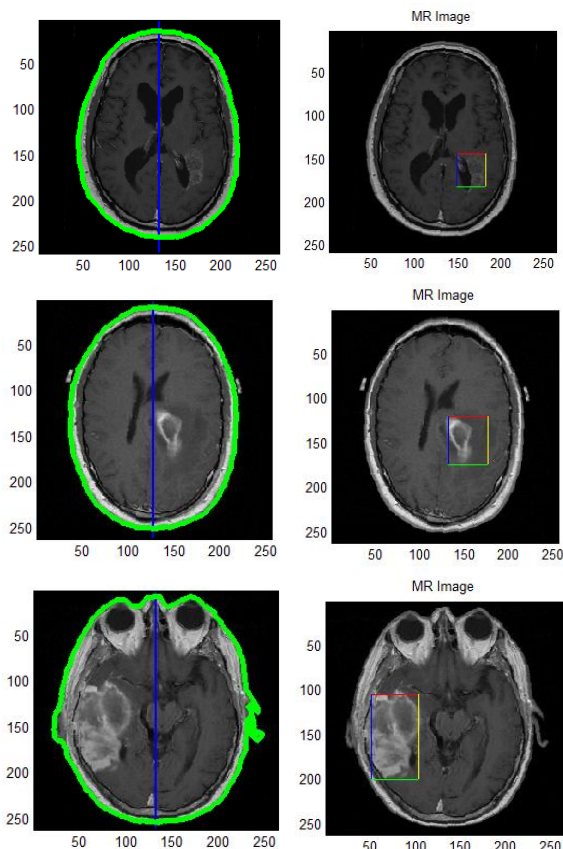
Partition of hemisphere of human brain and finally detected tumour and marked in rectangle box in different MRI images of different patient.
